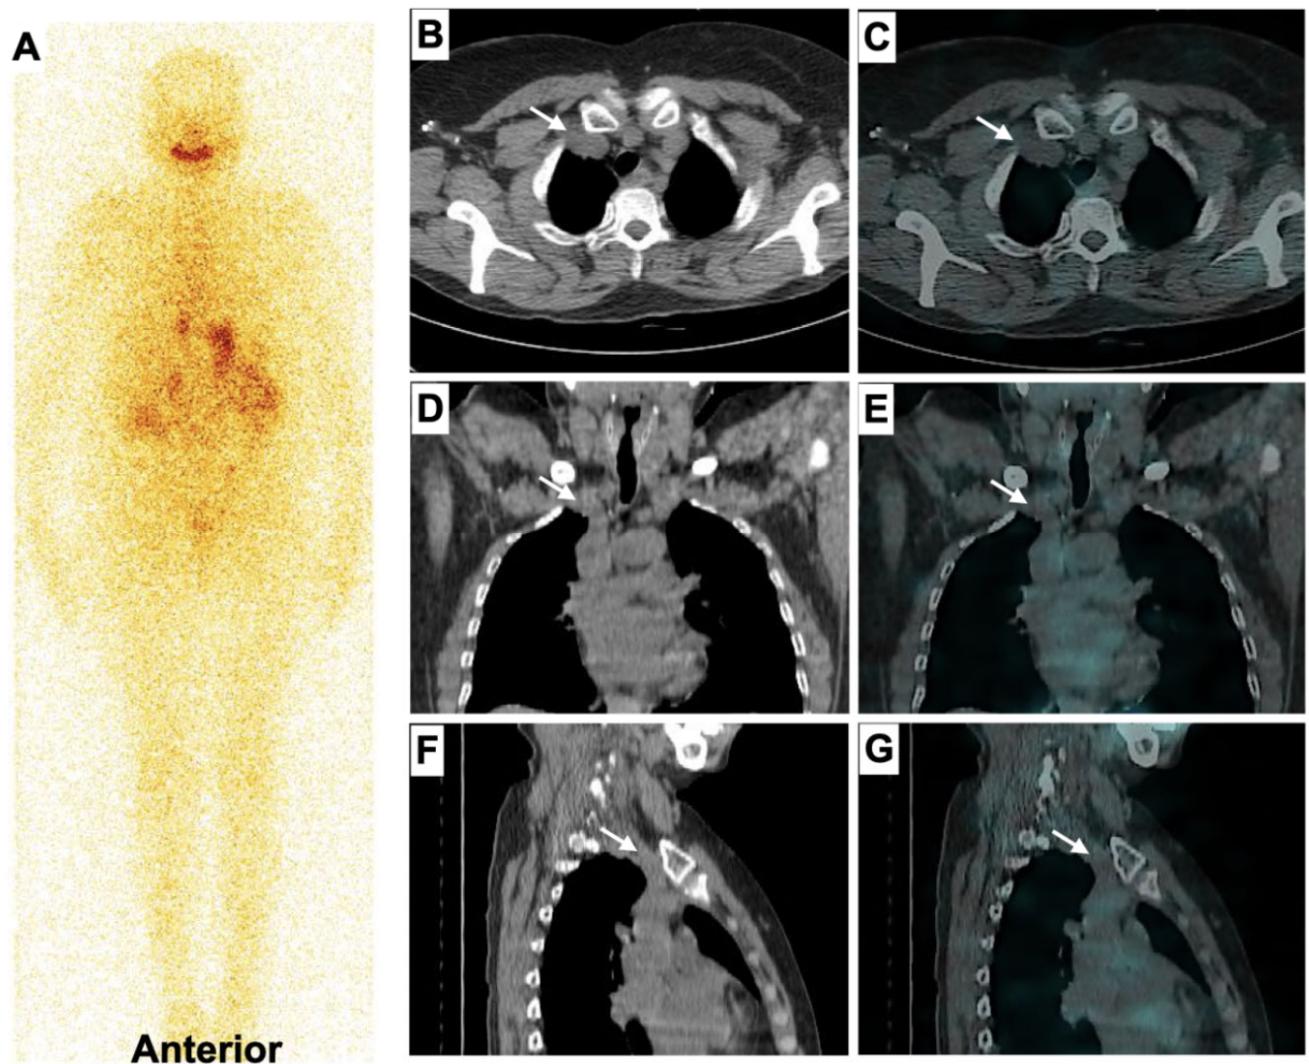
(A) Follow-up whole-body ^{131}I planar images, (B-G) CT and fused images on GE-Discovery 670-DR, showing complete resolution of tracer uptake and hyperdense lesion within the right brachiocephalic vein (arrows).
